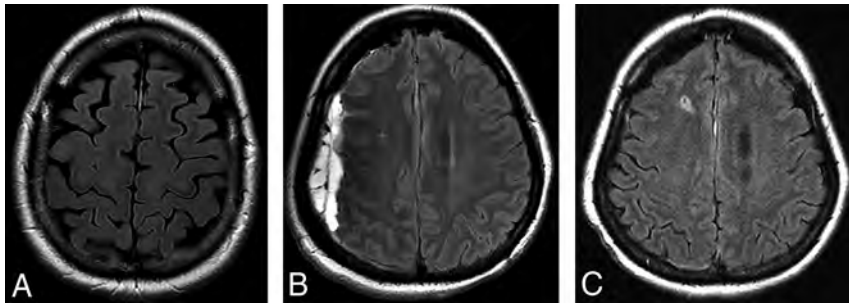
A, T2 FLAIR image in the same patient as in Fig 2A shows complete resolution of the white matter changes 2 years after resection of the lesion. B, T2 FLAIR image from a 53-year-old female patient with a spontaneous right-sided acute subdural hematoma. T2 hypointense signal changes are present in the subjacent white matter. C, Follow-up 5 months later shows resolution of both the hematoma and the white matter changes.
